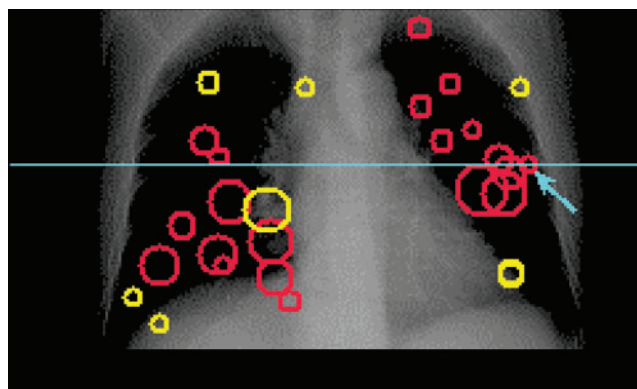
Overview of the computer-detected nodules indicated in a coronal view of the thorax CT data set.
